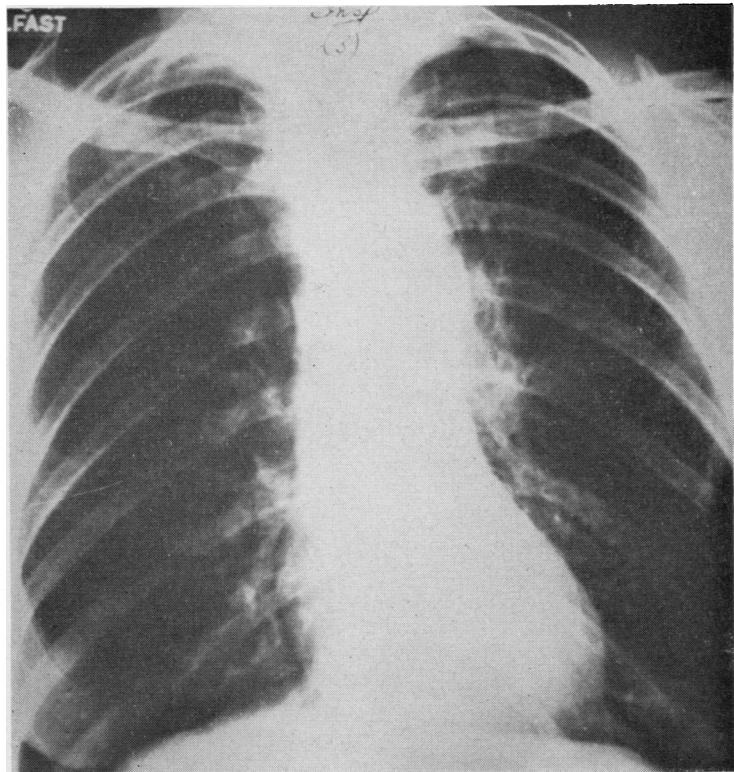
Case 10. Radiograph taken 27 April 1964 after the administration of 4.4 g. cyclophosphamide. There has been almost complete radiological regression.*
